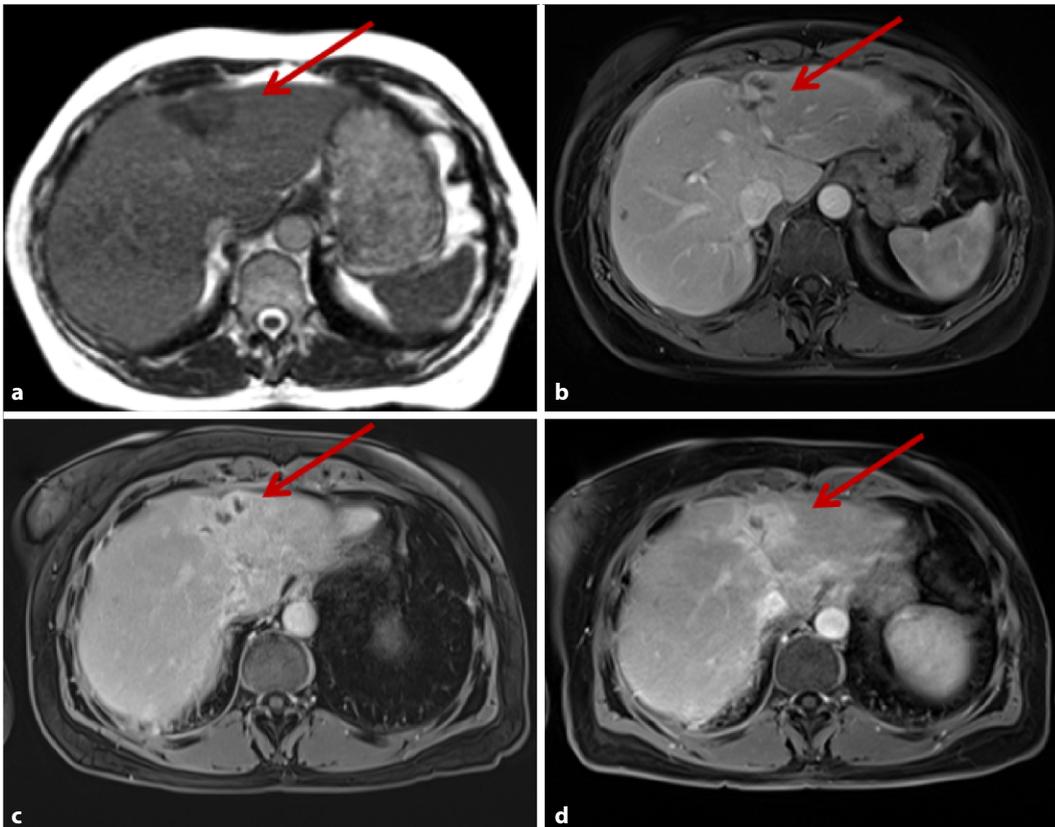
◀ Liver metastasis in segments II/IV (red arrow): a TrueFISP at the MR-Linac for treatment planning; b post-contrast T1-weighted image from clinical scanner for planning; c and d post-contrast T1-weighted images from clinical scanner 3 months and 9 months after MR-guided radiotherapy of the liver metastasis
